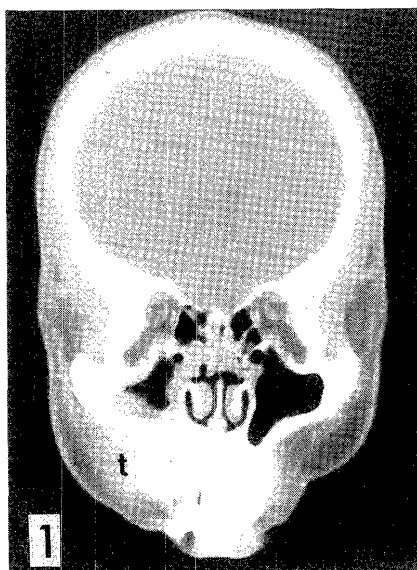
CT tomogram of the patient's head and face involving the maxillary lesion. The right maxillary sinus is narrowed by compression of the tumor proliferating expansively inside the bone (t).
